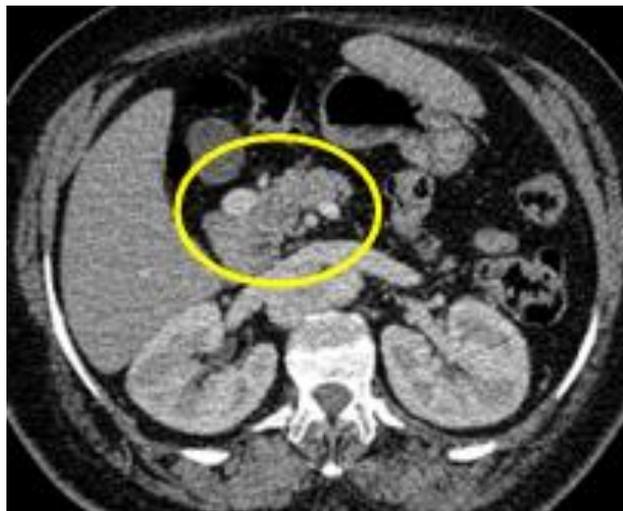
Contrast enhanced CT in axial section showing a short pancreas and a pre pancreatic PT.
